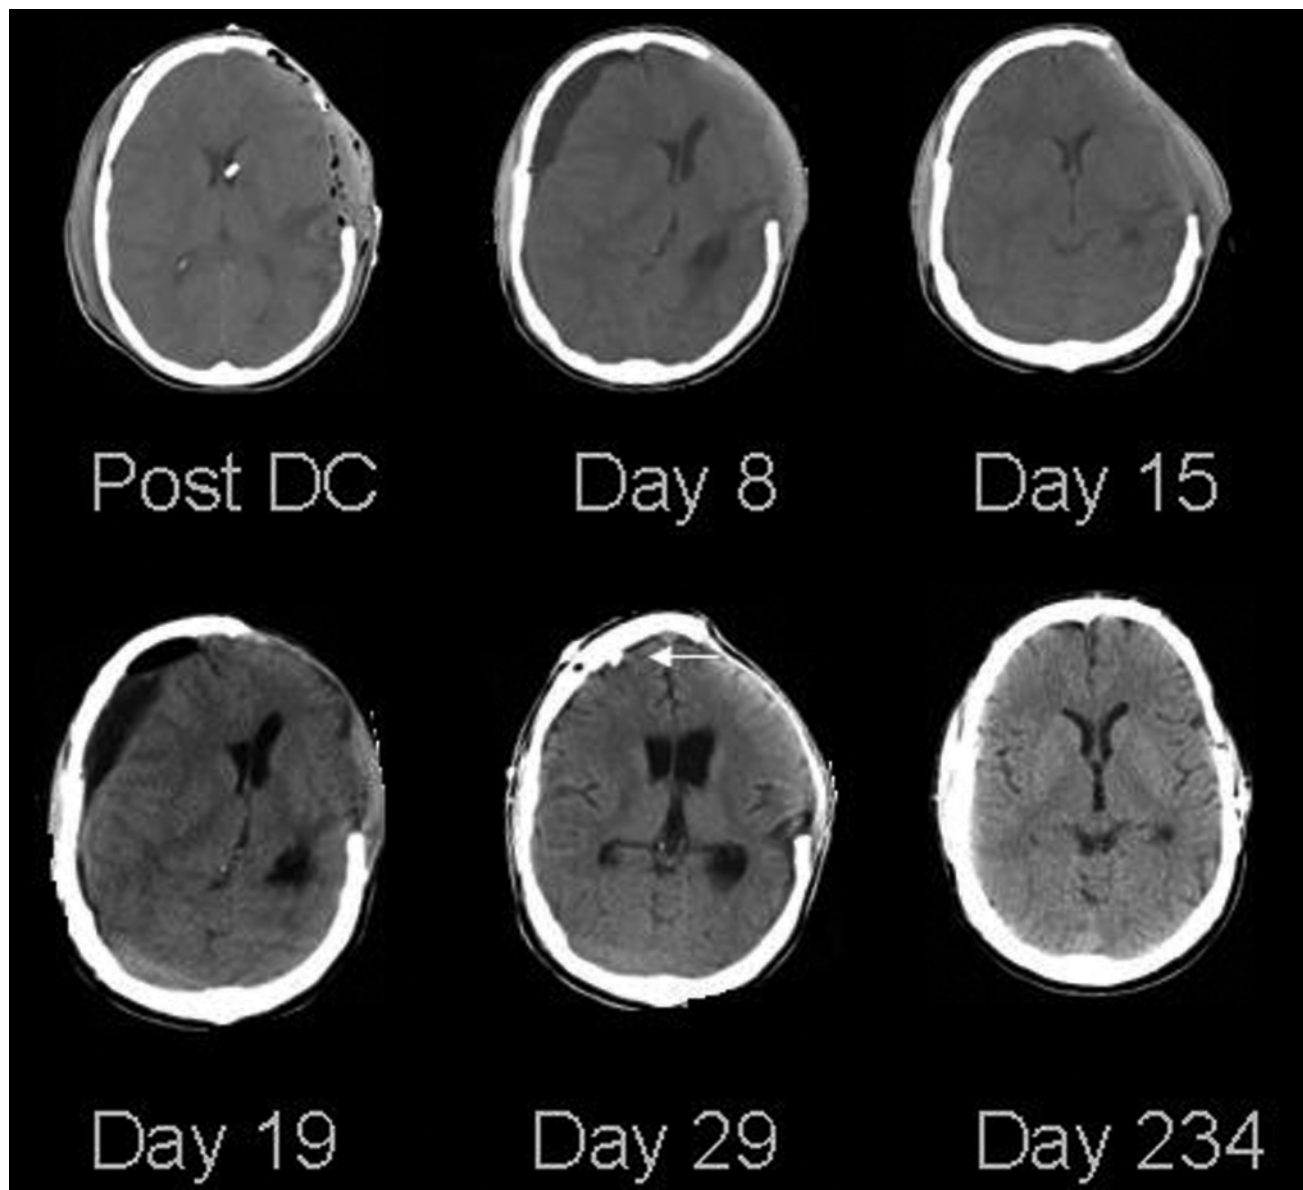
Noncontrast head CT scans obtained from a 24-year-old man who had been in an MVA for which he underwent DC in April 2000. His admission GCS score was 11 and the Injury Severity Score was 29. On Day 4 of his admission, he had to undergo urgent exploration because of neurological worsening. His postoperative clinical course was uneventful; however, on Day 8 after DC he underwent another CT study because of a decline in his mental status; the CT scan indicated evidence of an SDG with significant shift of the midline structures to the left. He underwent 2 attempts to evacuate the SDG by the insertion of a drainage system through a twist drill bur hole at bedside in the intensive care unit (arrow, Day 29). Eight months after the DC, he had an autologous cranioplasty. He remained neurologically intact 47 months after discharge from the institution.
